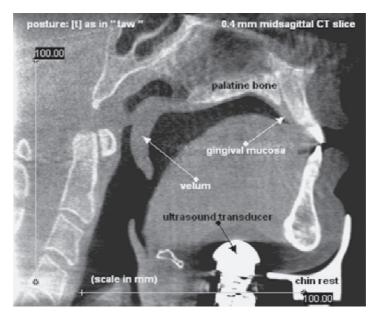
Midsagittal CT of vocal tract reconstructed from axial images. Bone is white; soft tissue is gray. (Reproduced courtesy of Ian Wilson)
